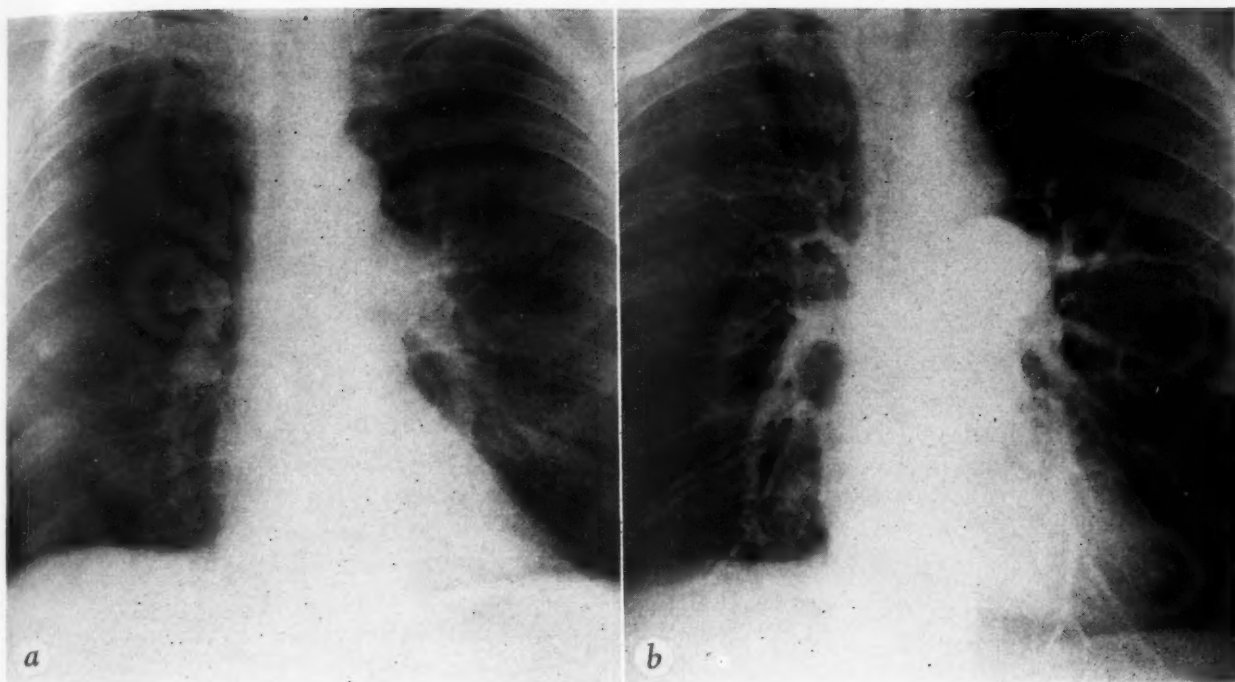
Case 3. (a) Roentgenogram of the chest. (b) Angiocardiogram.
